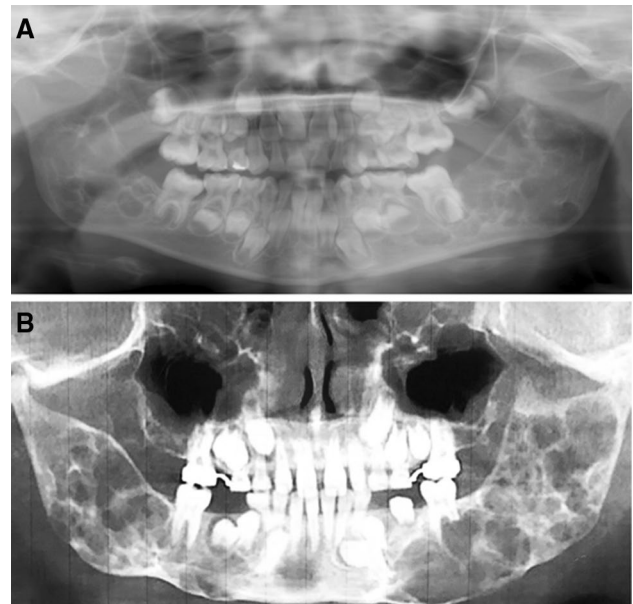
a, b Panoramic radiographs of the daughter of the proband (IV1) and her brother (IV2) disclosed multiple bilateral radiolucencies affecting the posterior portion and the ramus of the mandible
